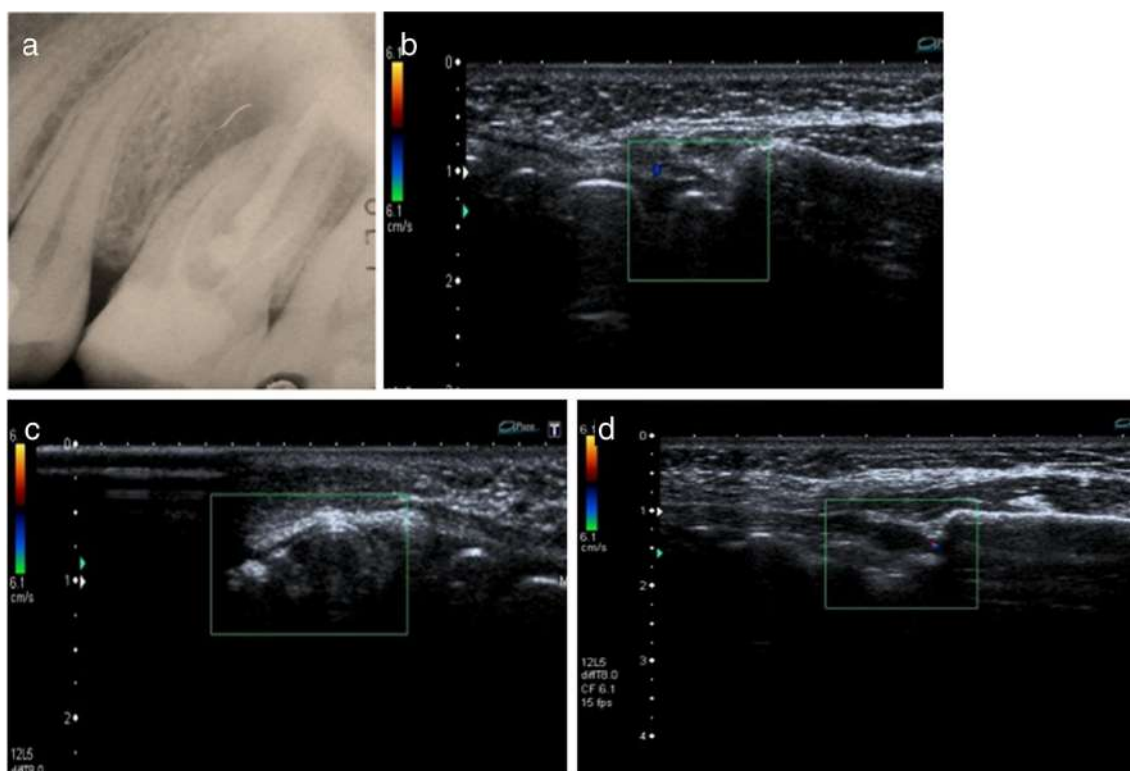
Negative control. a Preoperative periapical radiograph showing apical periodontitis. b No evidence of vascular changes within the lesion from t_0 , c at 1 week from t_0 , and d at 4 weeks from t_0
